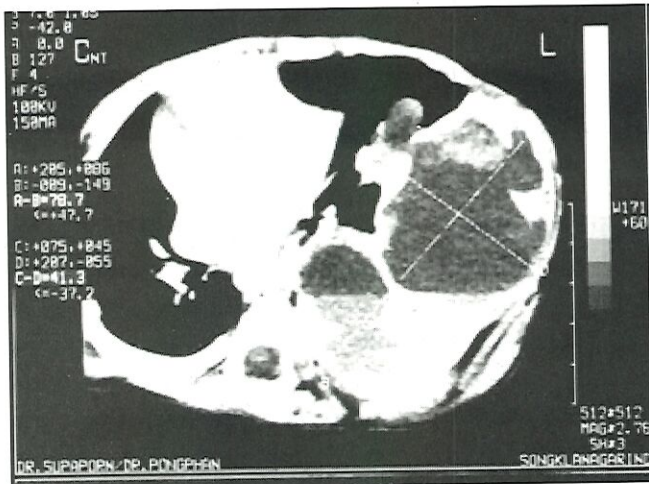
Chest CT scan showed a multi-locular chest wall mass with fluid level, surrounded by cortical bony rim. Adjacent rib destruction and mediastinal shifting are noted.
